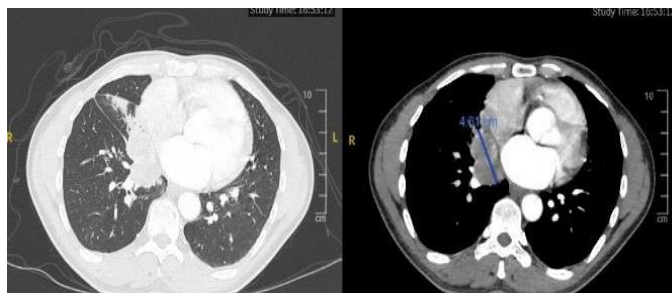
Thoracic CT scan examination August 3rd, 2022, fourth RECIST.
